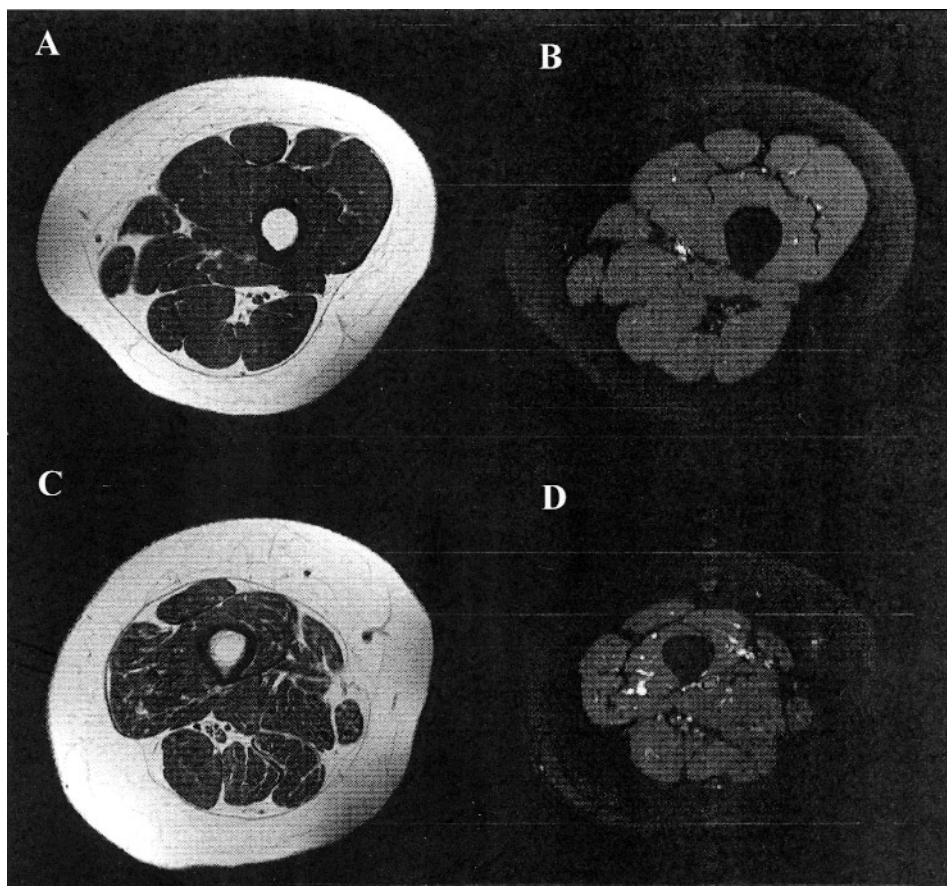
Axial T1 weighted spin echo (A) and axial turbo spin-echo STIR MR images (B) recorded in a patient (complaining of myalgia) and showing normal appearance of the thigh muscles with no evidence of edema, fatty infiltration, or atrophy. Axial T1 weighted spin-echo (C) and axial turbo spin-echo STIR MR images (D) recorded in another patient (with muscle weakness, amyotrophy, and pyramidal syndrome of the 4 limbs) showing clear diffuse muscle atrophy with fatty infiltration.
